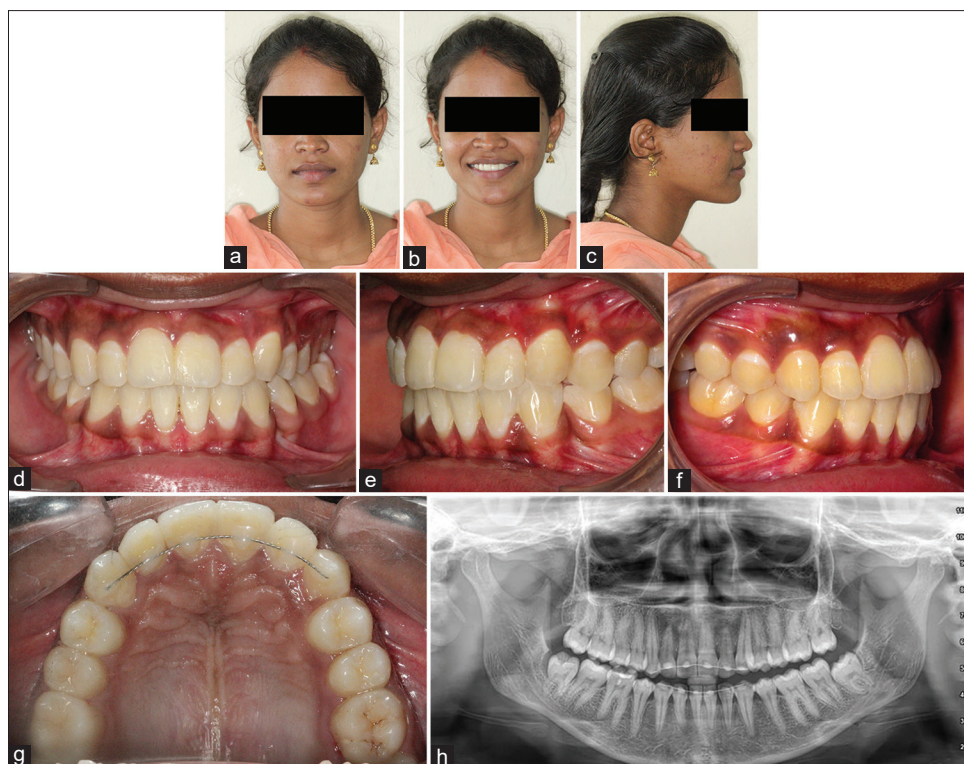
Posttreatment photos. (a) Extraoral frontal. (b) Extraoral smile. (c) Extraoral profile. (d) Intraoral frontal. (e) Left lateral. (f) Right lateral. (g) Upper occlusal. (h) Posttreatment orthopantomogram
